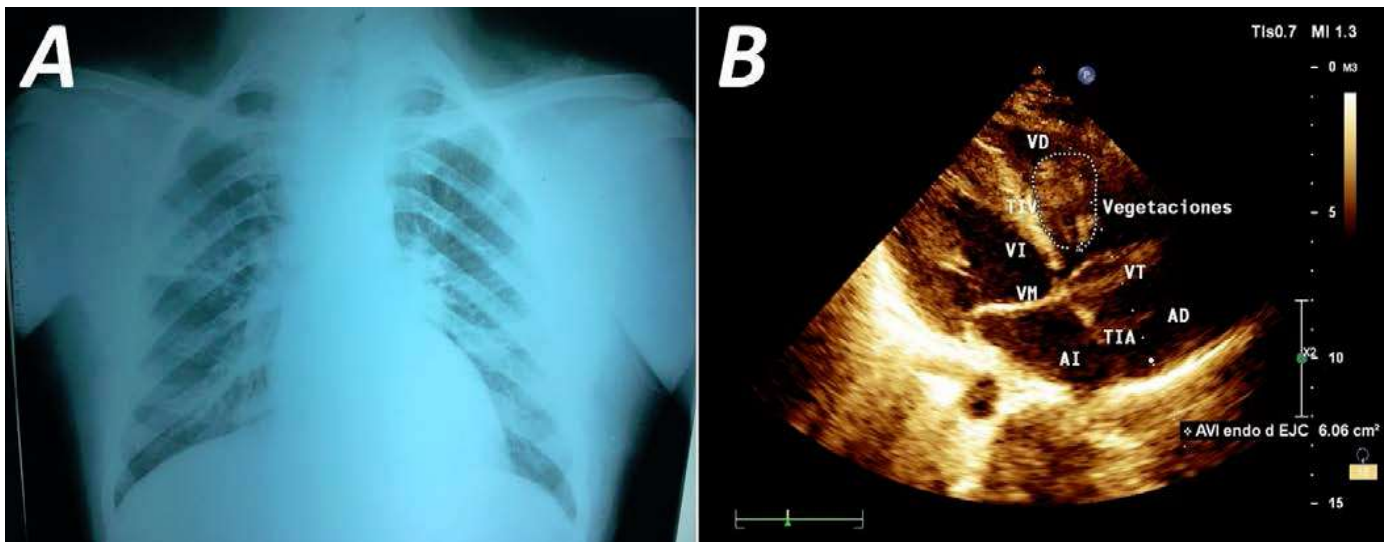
A. Posteroanterior chest radiography showing multiple lesions produced by embolic phenomena (possible right pulmonary infarction) due to right heart vegetation. B. Echodense image that suggests vegetation in the right ventricular, attached to the tricuspid valve, and severe tricuspid regurgitation. Acronyms in Spanish: *AD*, right atrium; *AI*, left atrium; *TIA*, interatrial septum; *TIV*, interventricular septum; *VD*, right ventricle; *Vegetaciones*; vegetations; *VI*, left ventricle; *VM*, mitral valve; *VT*, tricuspid valve.
